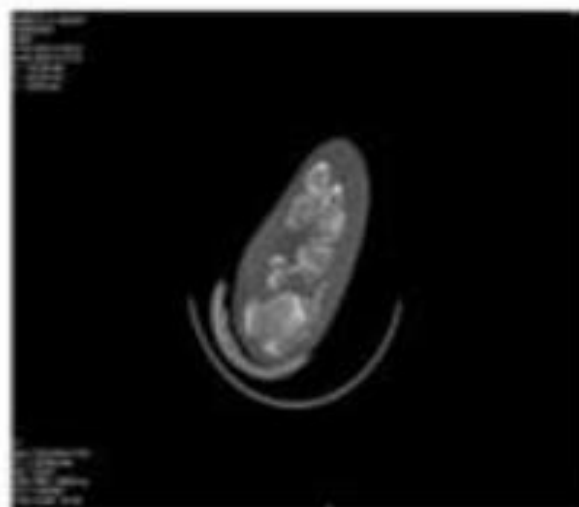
CT IMAGE SHOWING TYPE III FRACTURE
